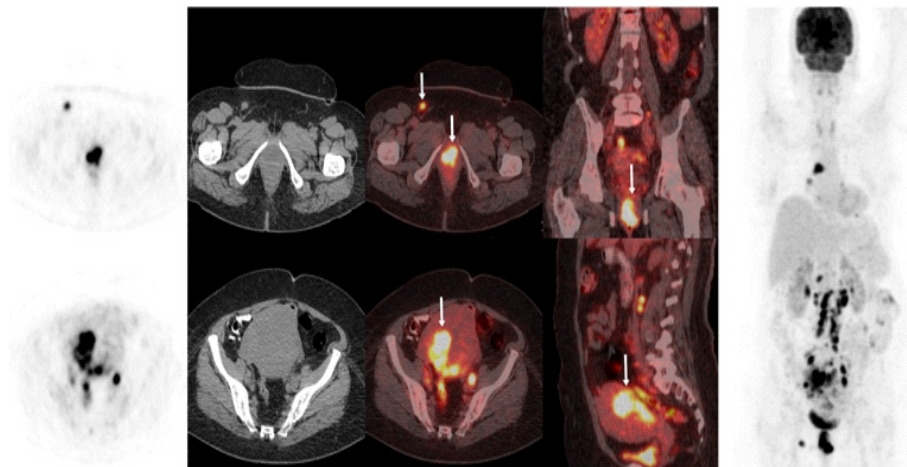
Fluorine-18-FDG PET/CT examination with highly increased ^{18}F -FDG uptake in the vagina and the uterine cavity with multiple metastases, easily visible on the MIP image (arrows).
